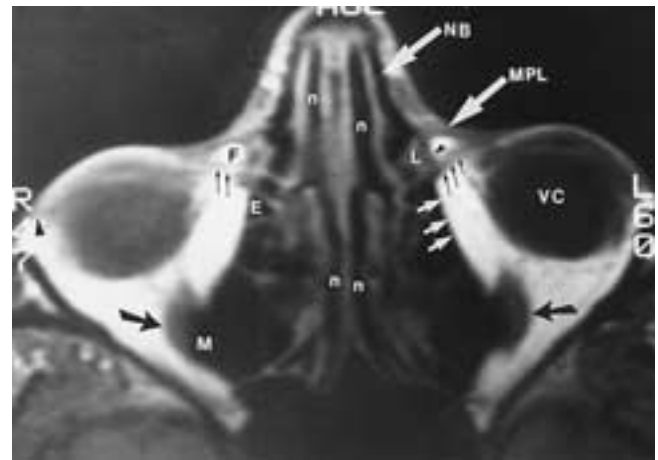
Normal MR imaging anatomy. T1-weighted MR image shows the nasal bone (*NB*); nasal cavities (*n*); medial palpebral ligament (*MPL*); lacrimal portion of the orbicularis oculi and orbital septum (*small black arrows*); lacrimal sac (*L*); lacrimal fascia (*small arrowhead*); periorbita (periosteum) (*three white arrows*); inferior rectus muscle (*large black arrows*); maxillary sinus (*M*); ethmoid air cells (*E*); nasal bone (*NB*); vitreous chamber of the eye (*VC*); fat pad (*F*) adjacent to the lacrimal sac; and the lateral palpebral ligament (*large black arrowhead*). The lacrimal sac is about 12 cm long, is situated in the lacrimal fossa, and is enclosed by the lacrimal fascia (*small black arrowhead*), which is attached behind to the posterior lacrimal crest of the lacrimal bone and in front to the anterior lacrimal crest of the maxilla. The fascia is formed from the periorbita (*three white arrows*).
